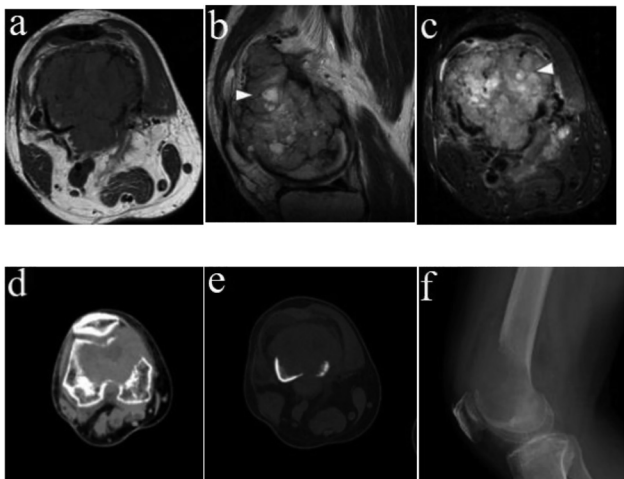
A 62-year-old man with osseous metastasis of ccRCC in his right femur. (A–C) Axial T1WI, sagittal T2WI, and axial fat suppression T2WI show a mass in the distal femur with heterogeneous hyperintensity and a curvilinear area of hypointensity on T2WI (arrowhead). (D–F) CT soft tissue window, CT bone tissue window, and lateral radiograph show an ill-defined osteolytic lesion with expansile change.
